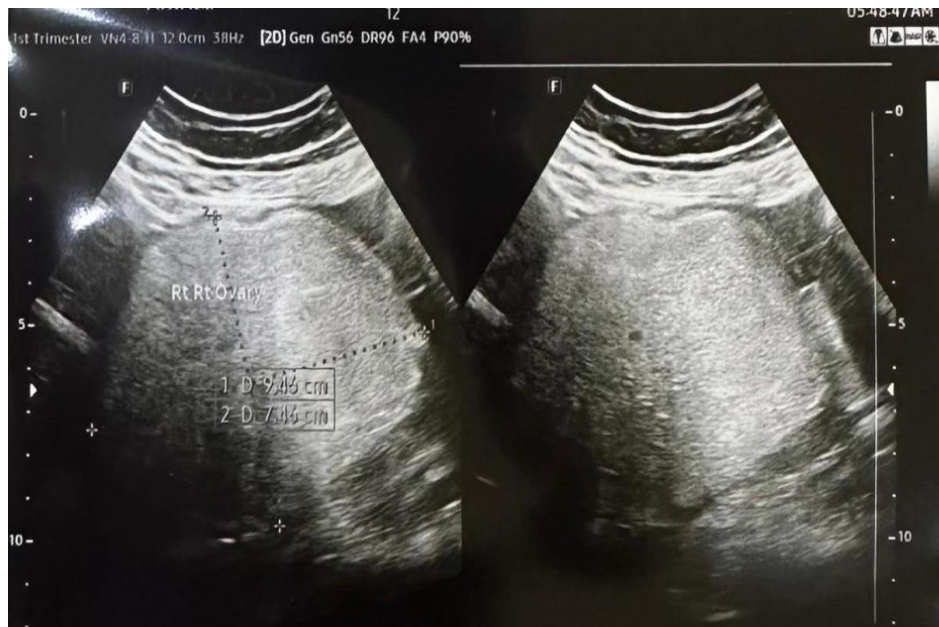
Trans abdominal ultrasound image for a 32-year-old female who presented with pelvis pain shows large solid mass measure (9.4 x 7.4 cm)
